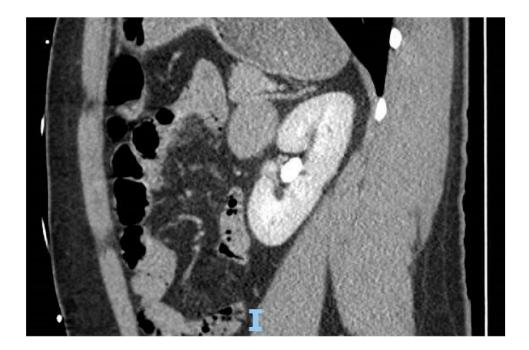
Computed tomography image of the left upper quadrant in sagittal view demonstrating a complex cystic mass adjacent to the left kidney.
